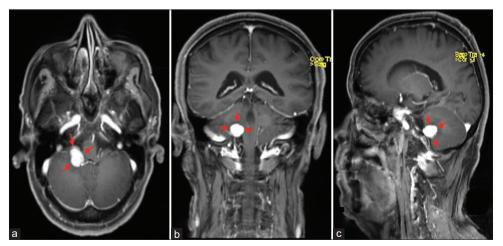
a-b Are preoperative MRI showing a nodular abnormal signal intensity at the right cerebellopontine angle (CPA) a = Axial, b = Coronal, c = Sagittal. Red arrows = lesion
